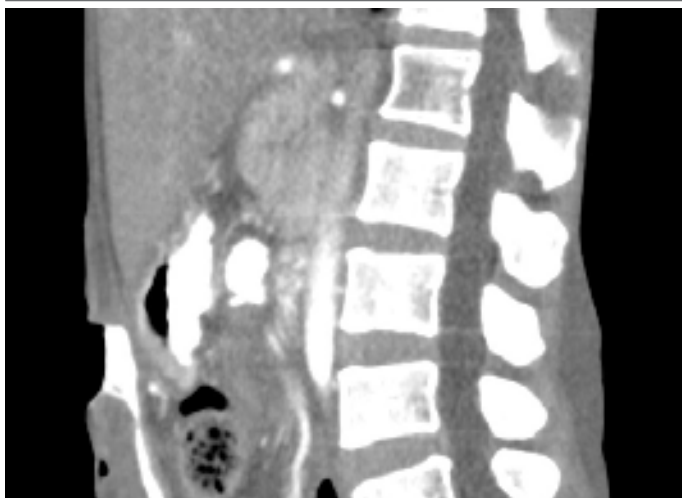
Axial view Contrasted CT. Images not to scale
